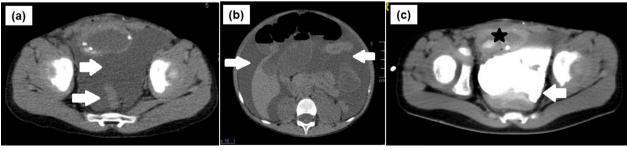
Non-contrast CT scan of the abdomen and pelvis a, b showing significant intraperitoneal free fluid (white arrows). CT cystogram c showing significant extravasation (white arrow) from the augmented bladder (black star)
